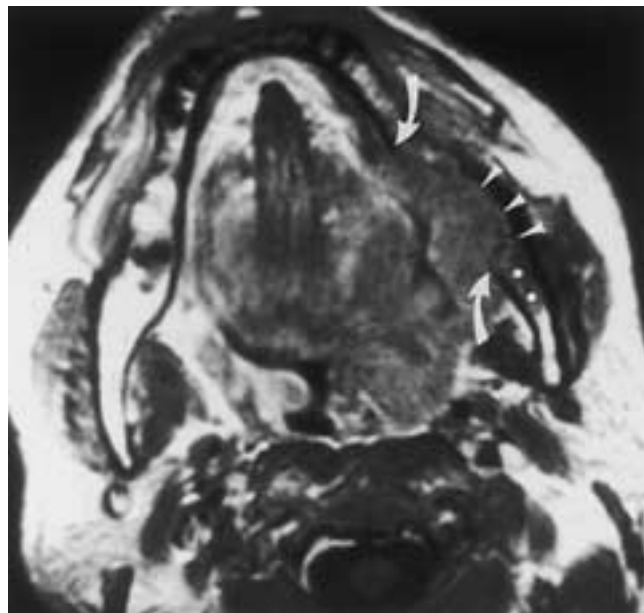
Squamous cell carcinoma invading the left mandible. Axial T1-weighted image demonstrates a large mass centered in the region on the tongue base and left tonsillar fossa with obvious erosion of a large portion of the lingual surface of the left mandible (curved white arrows). The tumor is visualized extending to the buccal cortex of the mandible (arrowheads). In addition, however, there is tumor extension into the posterior aspect of the mandible, replacing the normal high-signal fat, in an area where no lingual cortical mandibular destruction is identified (white dots).
